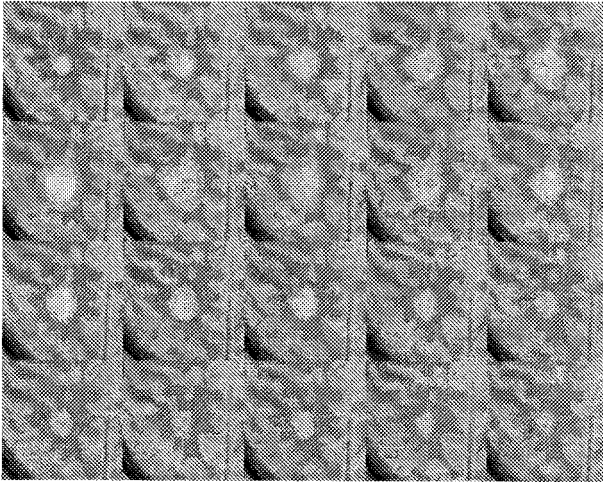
The same ROI in the 20 successive images of the same patient (T2-weighted, first echo).
